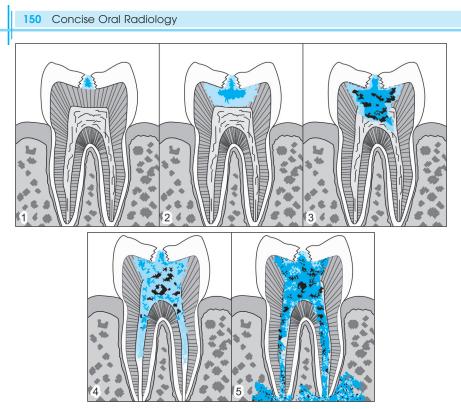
Progression of dental caries: (1) Enamel caries; (2) Dentinal caries; (3) Caries involving the pulp; (4) Infection spreading to the root canals; (5) Periapical infection. (*Source:* Internet)
